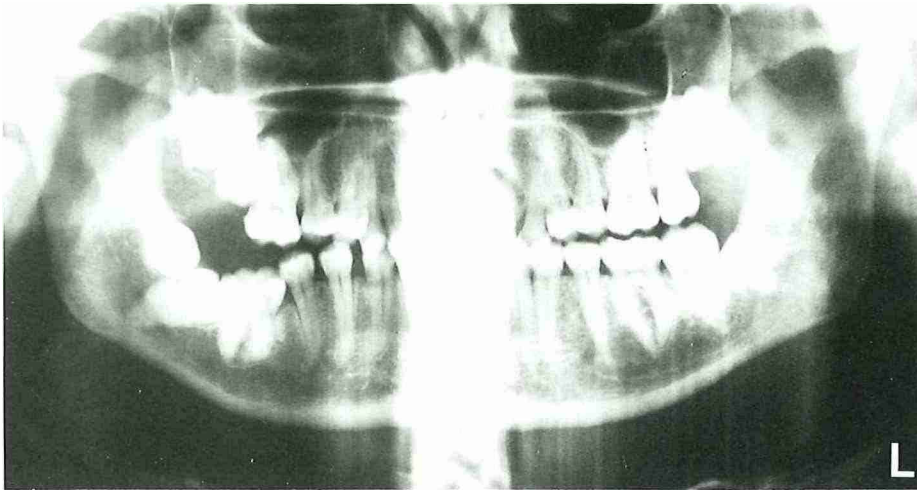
Orthopantomogram of a 36-year-old man showing secondary retention of the mandibular right first molar and maxillary right second molar, and horizontal impaction of the mandibular right second molar.
